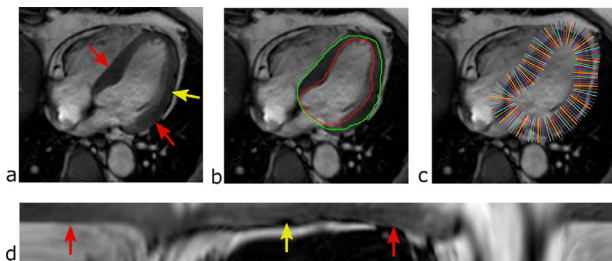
A random diastolic HLA MR image (a). The initial endocardial and epicardial contours obtained after the multi-atlas segmentation (b). The sampling profile lines computed from the smoothed endocardial contour (c). The profile image resulting from sampling along the profile lines (d). Red arrows indicate edges of soft tissue, while yellow arrows indicate dark lines caused by chemical shift. (For interpretation of the references to color in this figure legend, the reader is referred to the web version of this article.)
